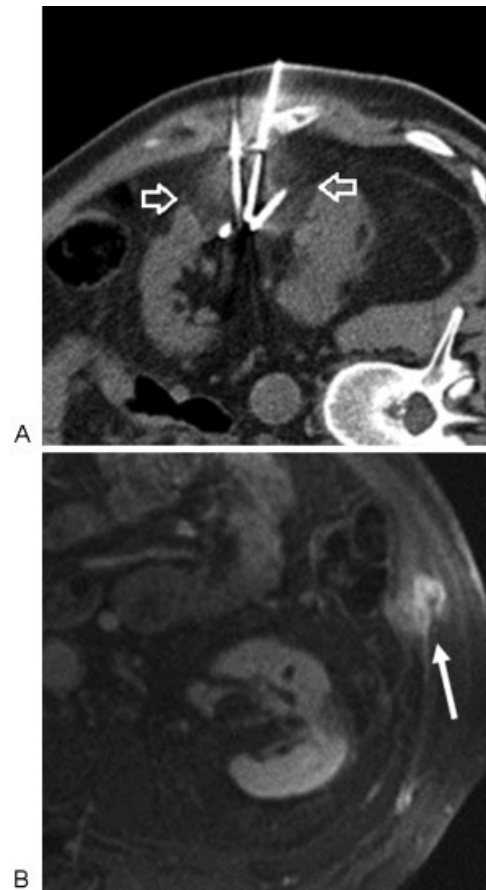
Tumor seeding following cryoablation. (A) CT image shows multiple cryoprobes entering through the left anterolateral abdominal wall and an ice ball (arrows) encasing a 3.5-cm left renal cell carcinoma in an 81-year-old man. (B) Postgadolinium MR image shows an enhancing 2-cm nodule (arrow) in the abdominal wall at the site of prior cryoprobe placement. Biopsy confirmed metastatic RCC, and the nodule was then successfully treated with cryoablation. CT, computed tomography; MR, magnetic resonance; RCC, renal cell carcinoma.
